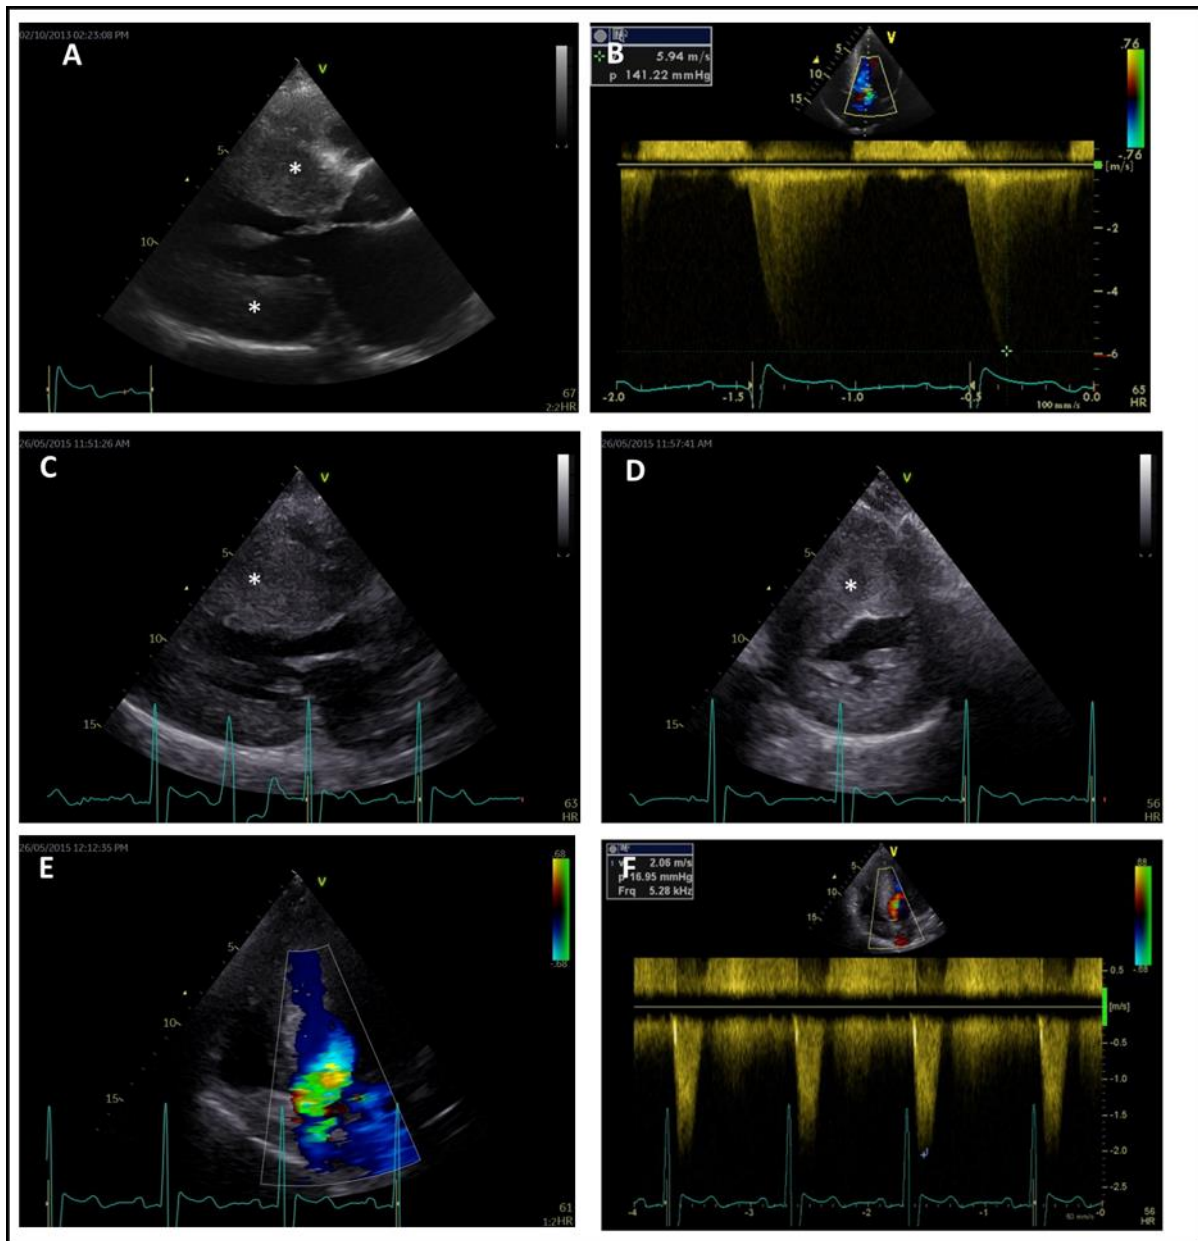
Echocardiographic images of patient 1, Related to Figure 1. Transthoracic echocardiographic imaging of patient 1 (Noonan syndrome, *RAF1*, male, 165 months of age) at the time of admission to the hospital for surgical left ventricular outflow tract resection (panel A and B), and at the time of follow-up (184 months of age, panel C, D, E and F). Depicted are the parasternal long axis view (panel A and C), parasternal short axis view (panel D), and the apical 5-chamber view (panel B and E) with color Doppler (panel E) and continuous wave (CW) Doppler (panel B and D) imaging. There is severe myocardial thickening (*), the peak gradient over the left ventricular outflow tract measures 130 mmHg before resection of the left ventricular outflow tract (panel B). There is no obstruction of the left ventricular outflow tract at the time of follow-up (panel F).
